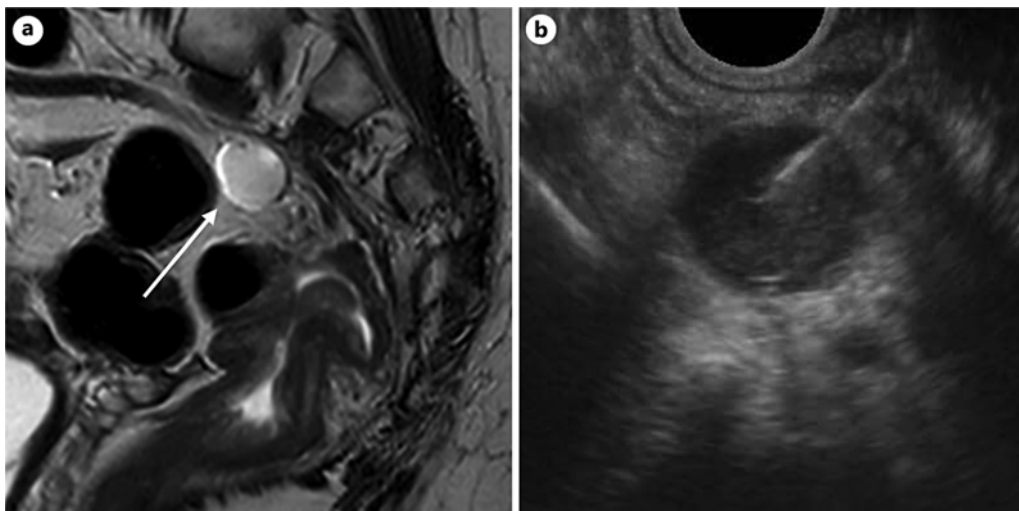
a, b MRI and EUS-FNA images of a suspected lymph node in the perirectal fat.
